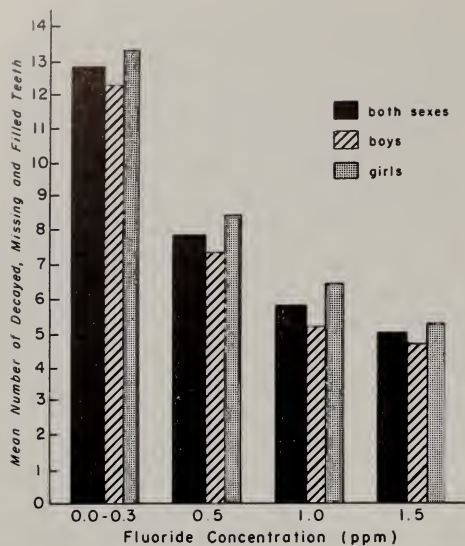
Mean number (without radiographs) of decayed, missing, and filled teeth for children classified according to the concentration of fluoride in the municipal water supplies.
